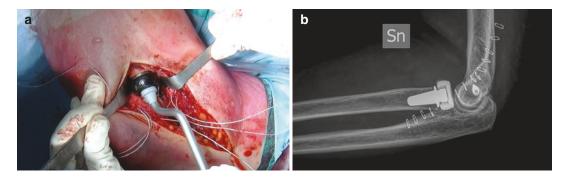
(a) Implantation of the final non-anatomical press-fit redial head. In this case a pyrocarbon implant was preferred due to the young age of the patient. (b) Postoperative X-ray
